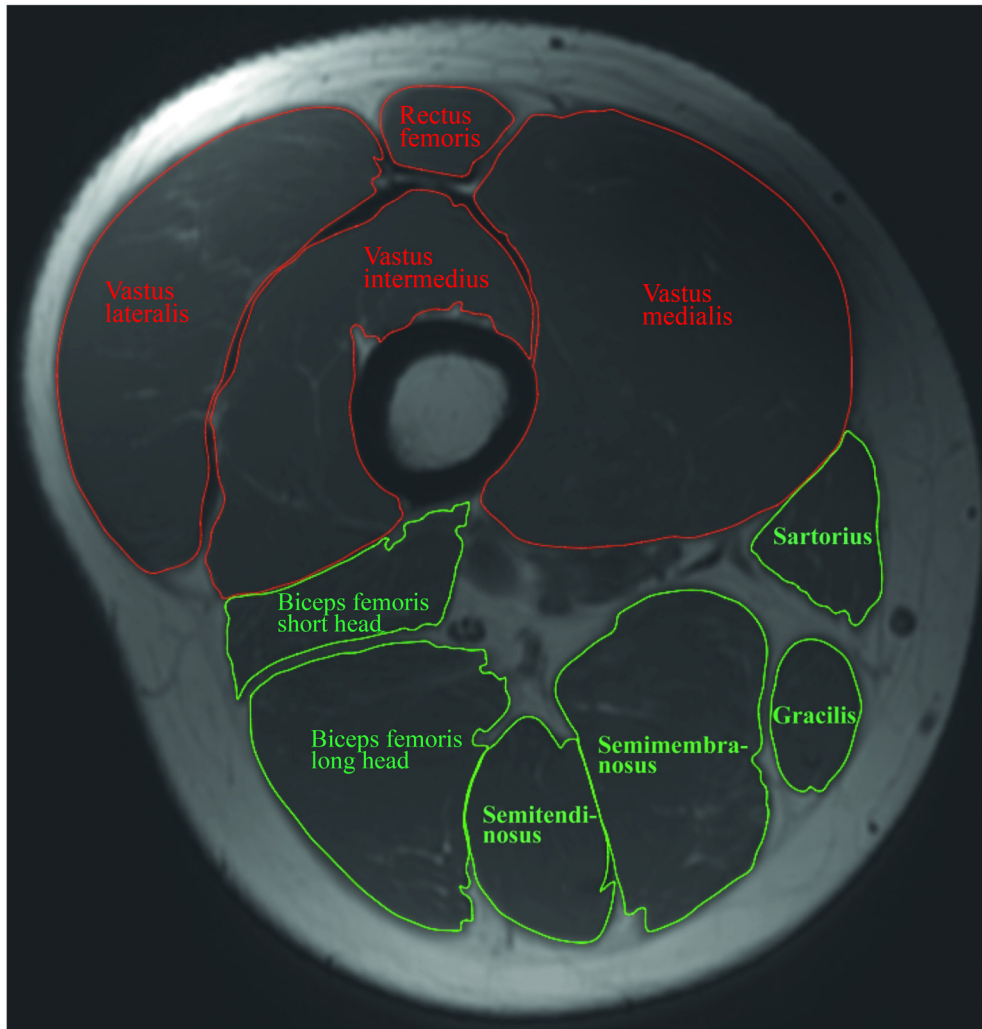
An example cross-sectional MRI image of the right thigh to show knee flexor and extensor muscles' cross-sectional areas for future use in muscle volume calculations. MRI indicates magnetic resonance imaging.
